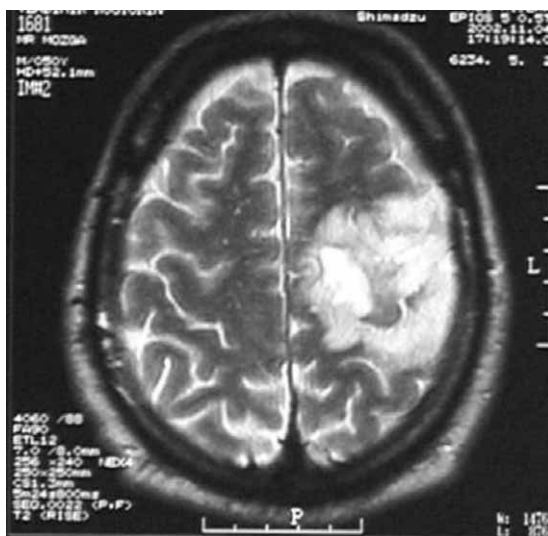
MRI in 2002 showed the expansive cystic formation at the same localization.
